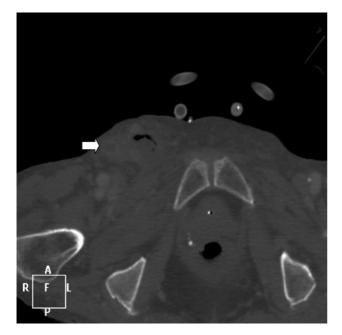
Transverse computed tomography (CT) image demonstrating femoral hernia and appendix (*arrow*)
